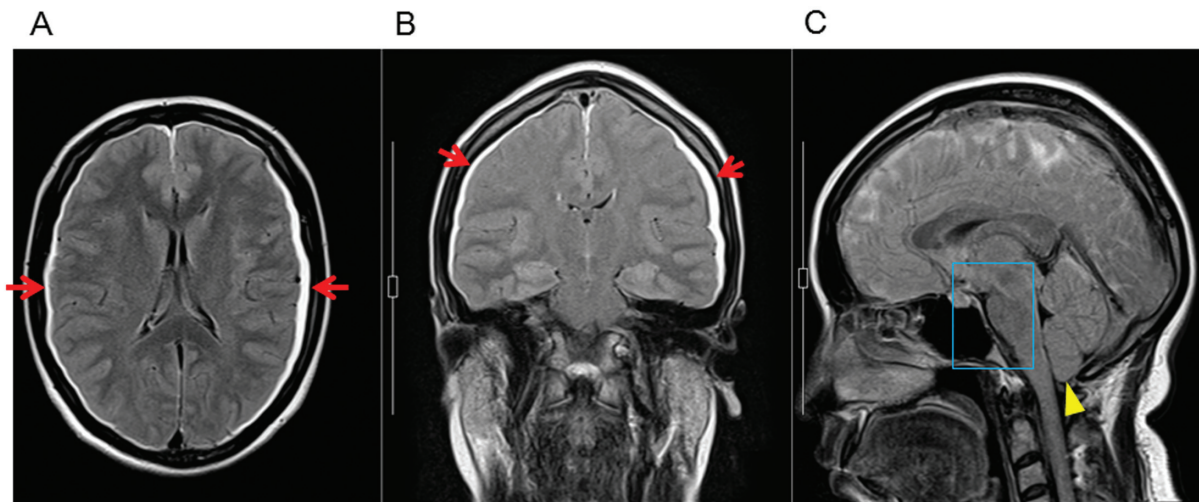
Magnetic resonance imaging (MRI) of the brain at presentation using fluid attenuated inversion recovery pulse sequence in case 1. Bilateral subdural effusion (arrows) is observed on axial (A) and coronal (B) scans. Sagittal scan (C) showing effacement of the basal and prepontine cisterns (box) and sagging of the cerebellar tonsils (arrowhead).
